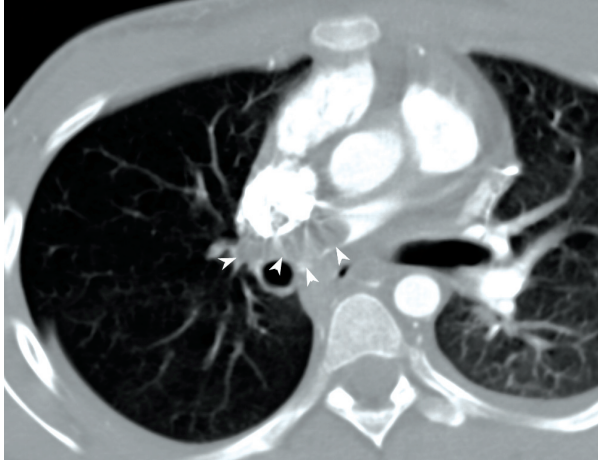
Contrast-enhanced CT scan of chest demonstrates a thrombus in the right main pulmonary artery (arrowheads) with diminished arterial perfusion of the right lung.
